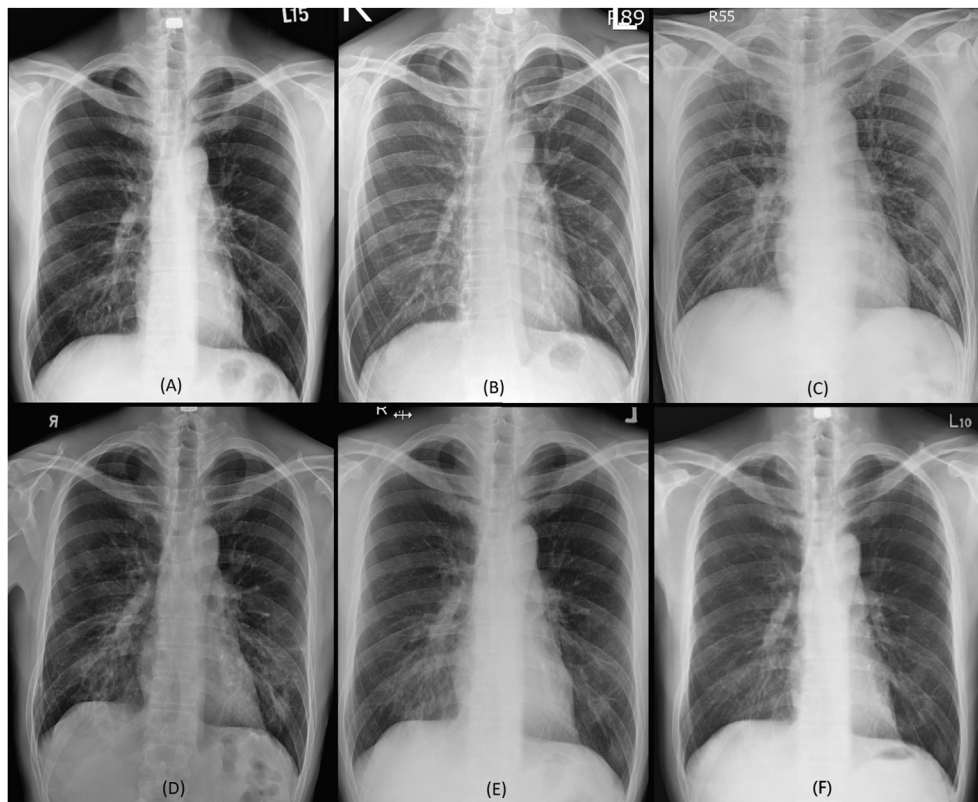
Chest radiographs two months prior to COVID-19 (A), and on the day of admission (B), initiation of corticosteroids (5th hospital day) (C), discharge (18th hospital day) (D), after a 2-week anti-tuberculous therapy (41 days of diagnosis of COVID-19) (E) and after a 6-week anti-tuberculous therapy (69 days of diagnosis of COVID-19) (F).
